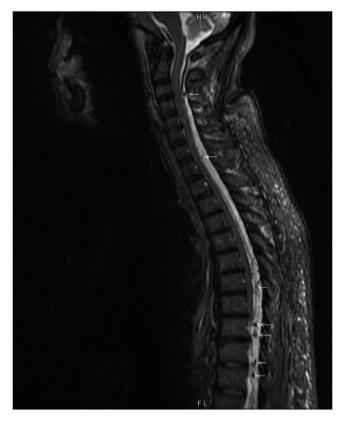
Sagittal view of gadolinium-enhanced magnetic resonance imaging of the cervical and thoracic spine showing multiple peripherally enhanced fluid collections (arrows) extending from C3 to T12 spine in the dorsal epidural space.
